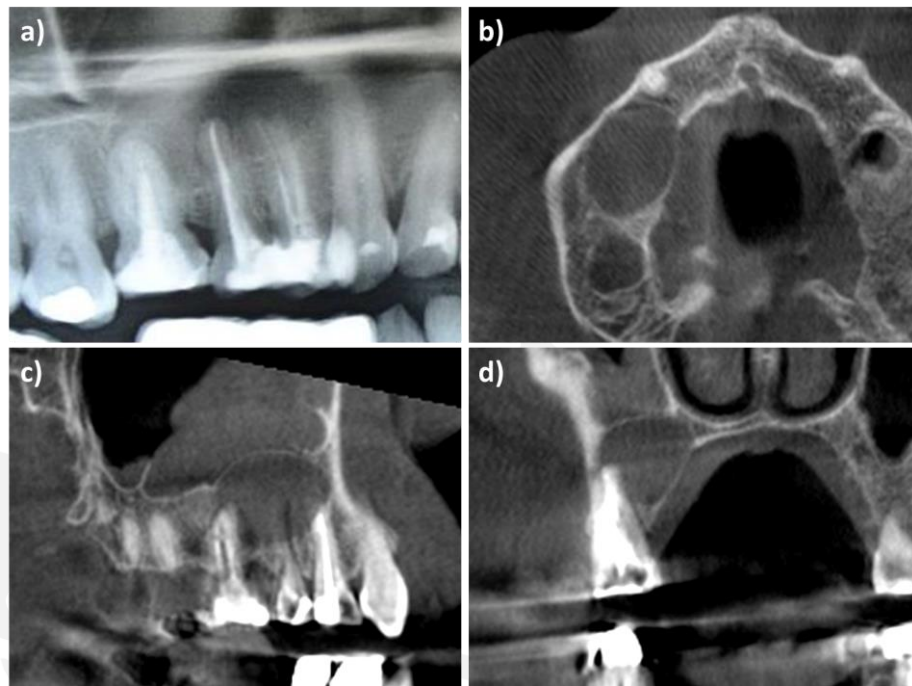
radiological examinations. a) detail of the dental radiograph at the first clinical examination; b) c) d) 3D CBCT scan before surgery.
